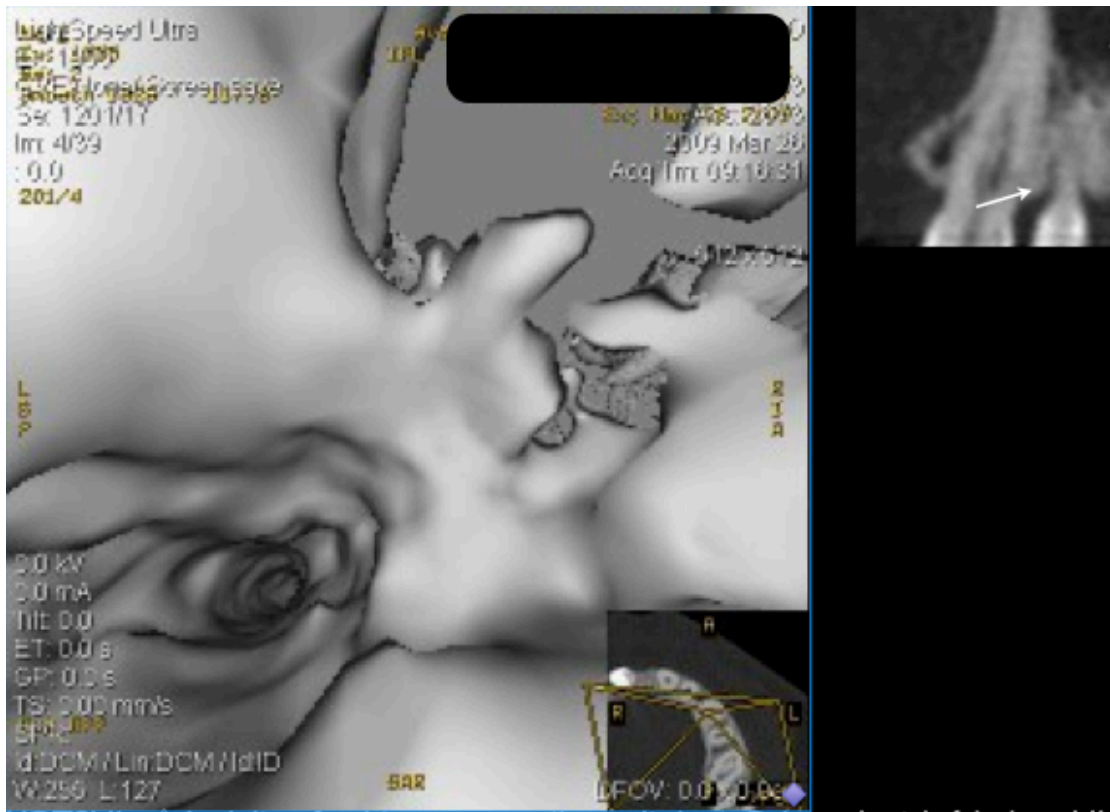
Tooth 21: 3-D image conversion of the CT-scan. The small picture on the right side with the arrow, is indicating where inside the canal the image is representing.
